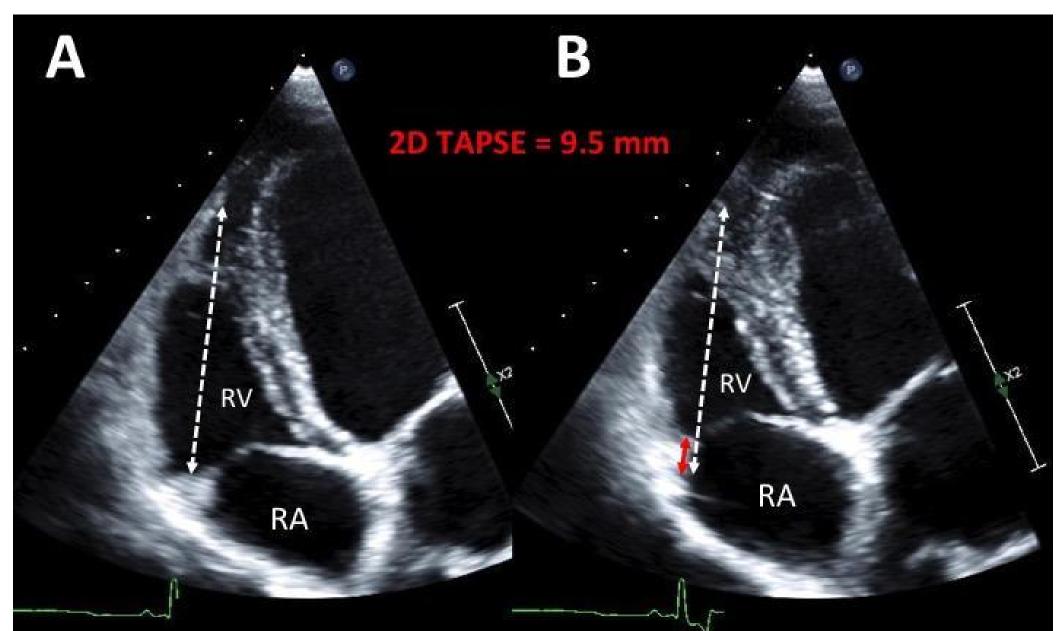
Representative measurement of 2D echocardiography-derived TAPSE (2D TAPSE).
